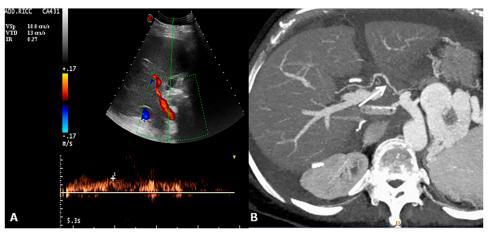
Hepatic artery stenosis. Colour and spectral Doppler image of hepatic artery shows a *tardus-parvus* waveform with a prolonged acceleration time and decreased resistive index 0.27 (normal range, 0.5–0.8). Axial maximum intensity projection of the hepatic artery shows tiny calibre and irregular margins of the arterial vessel (arrow).
